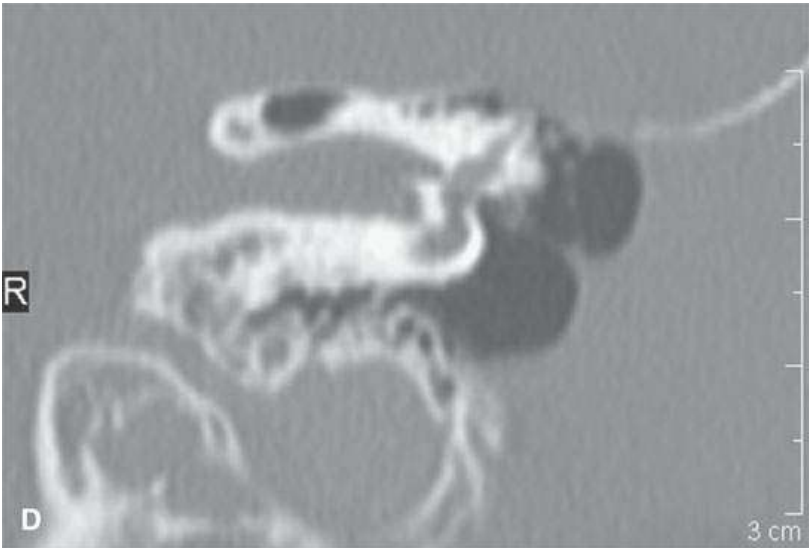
Computed tomography of a patient with a low-grade squamous cell carcinoma of the external auditory canal. A, B: Chronic bone erosion (arrows) and tumor confined lateral to the tympanic membrane, making a lateral temporal bone resection adequate for treatment. C, D: The patient status post lateral temporal resection that controlled the tumor.
